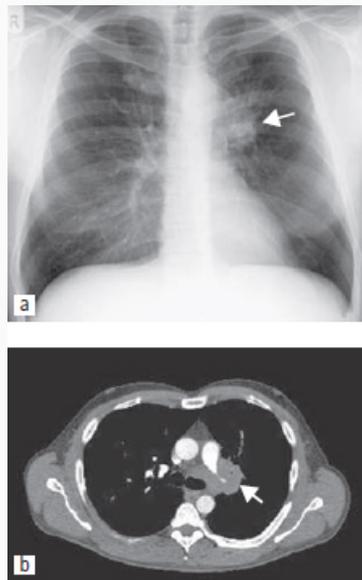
Chest radiograph (a) and computed tomography scan (b) showing a lung cancer at the left hilum invading the left pulmonary artery (white arrow).
